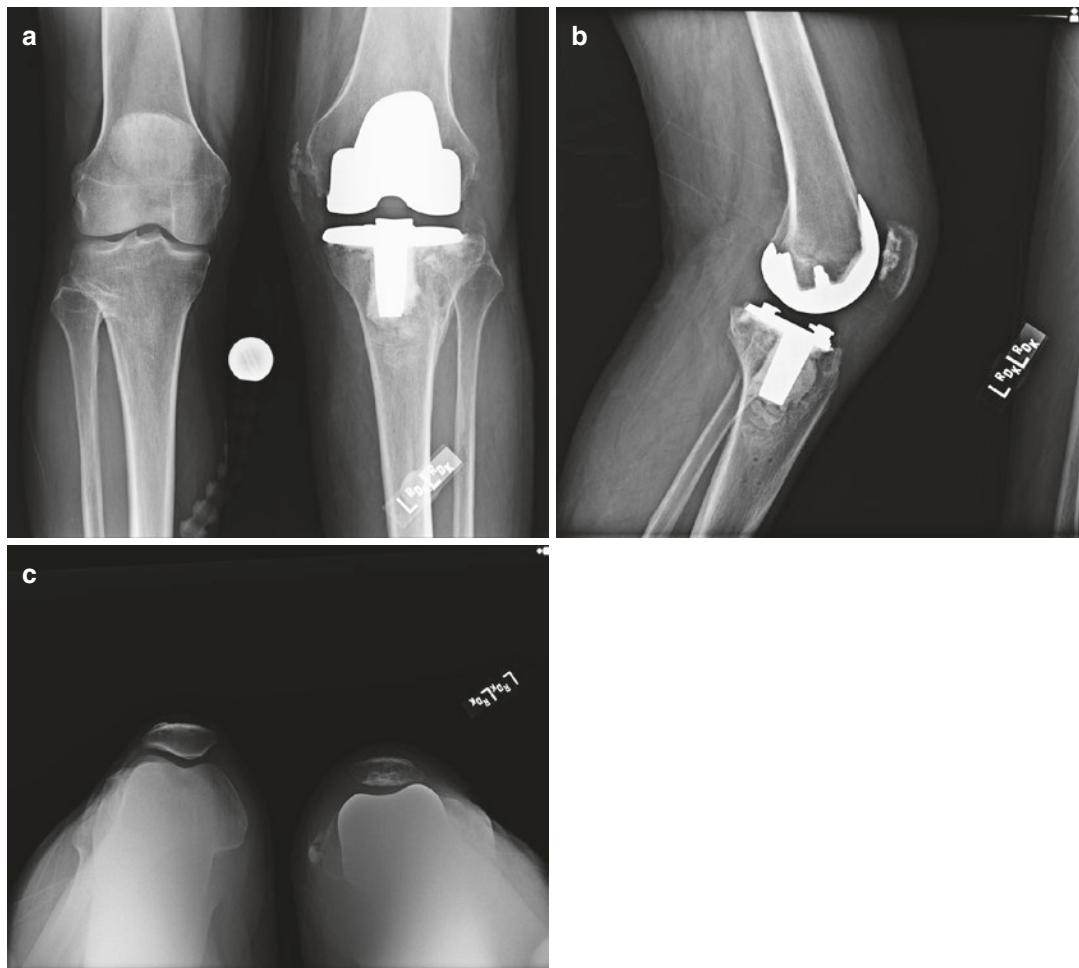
Radiographs postoperative to total knee arthroplasty: (a) standing anteroposterior view of both knees, (b) lateral view of the left knee, (c) merchant patellar view of both knees
